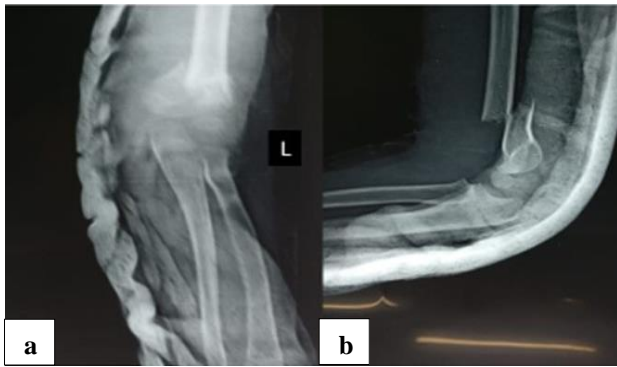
(a and b): Pre-operative X-ray.
